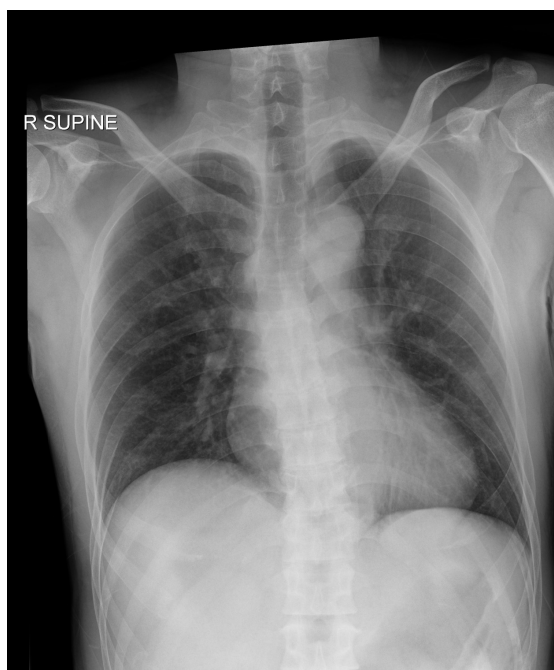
Supine chest radiograph without subdiaphragmatic free gas.*
